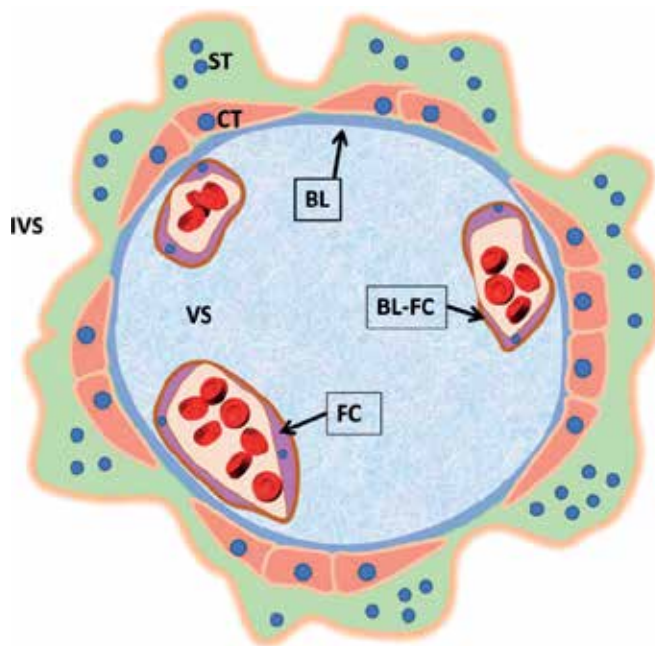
The placental barrier: the placental barrier is formed by the trophoblast composed by the superficial syncytiotrophoblast (ST) that contacts the maternal blood in the intervillous space (IVS) and the cytotrophoblast (CT) which corresponds to the germinative layer of the epithelium. The trophoblast is supported by the fetal connective tissue of the villous stroma (VS) that contains the fetal capillaries (FC). The placental barrier presents also two basal membranes (BM): (1) between villous stroma and trophoblast and (2) around fetal endothelium. The cells of the CT proliferate and afterward differentiate into the ST. The continuous incorporation of CT cells into the ST is counterbalanced by the formation of apoptotic ST knots, which are released into the IVS.
